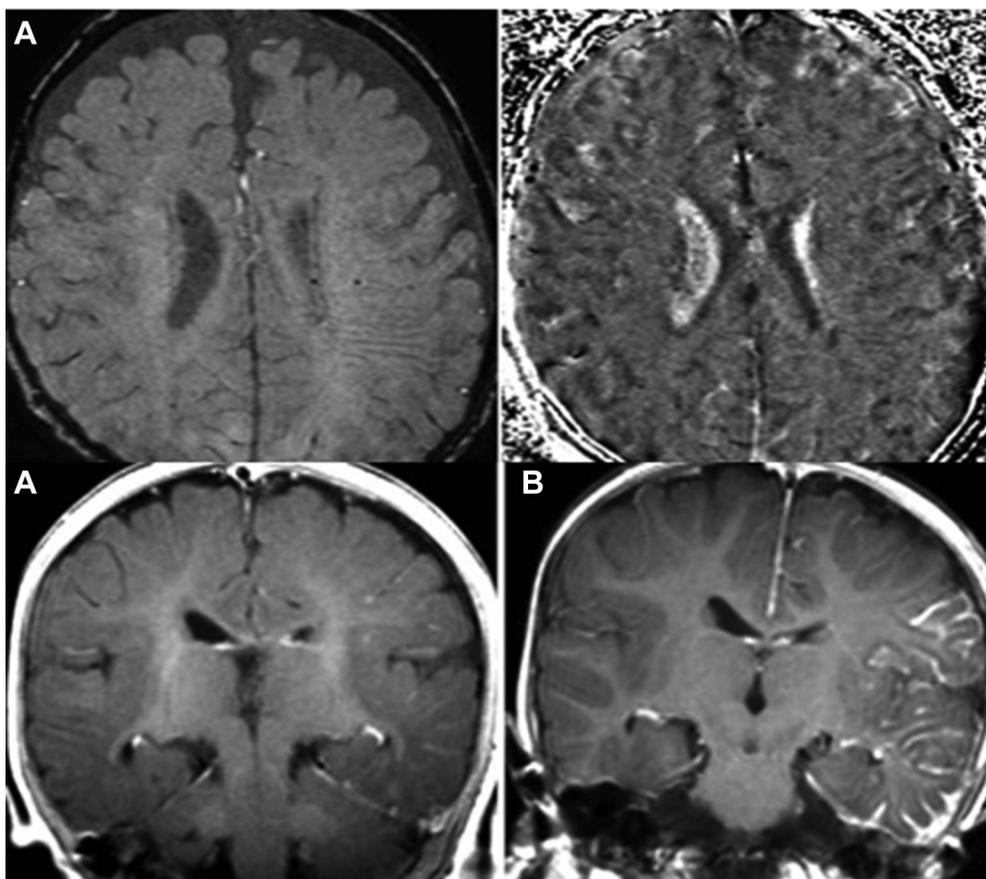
(A) Detection of enlarged deep medullary veins by susceptibility-weighted imaging (upper panels) in the left hemisphere of a four-month-old girl before the first seizure. Post-contrast T1-weighted MRI at the same age showed no clear abnormalities (lower left panel). (B) Postcontrast T1-weighted magnetic resonance imaging showed leptomeningeal enhancement only eight months later, after the first clinical seizure (adopted from Mentzel et al.¹⁶).
